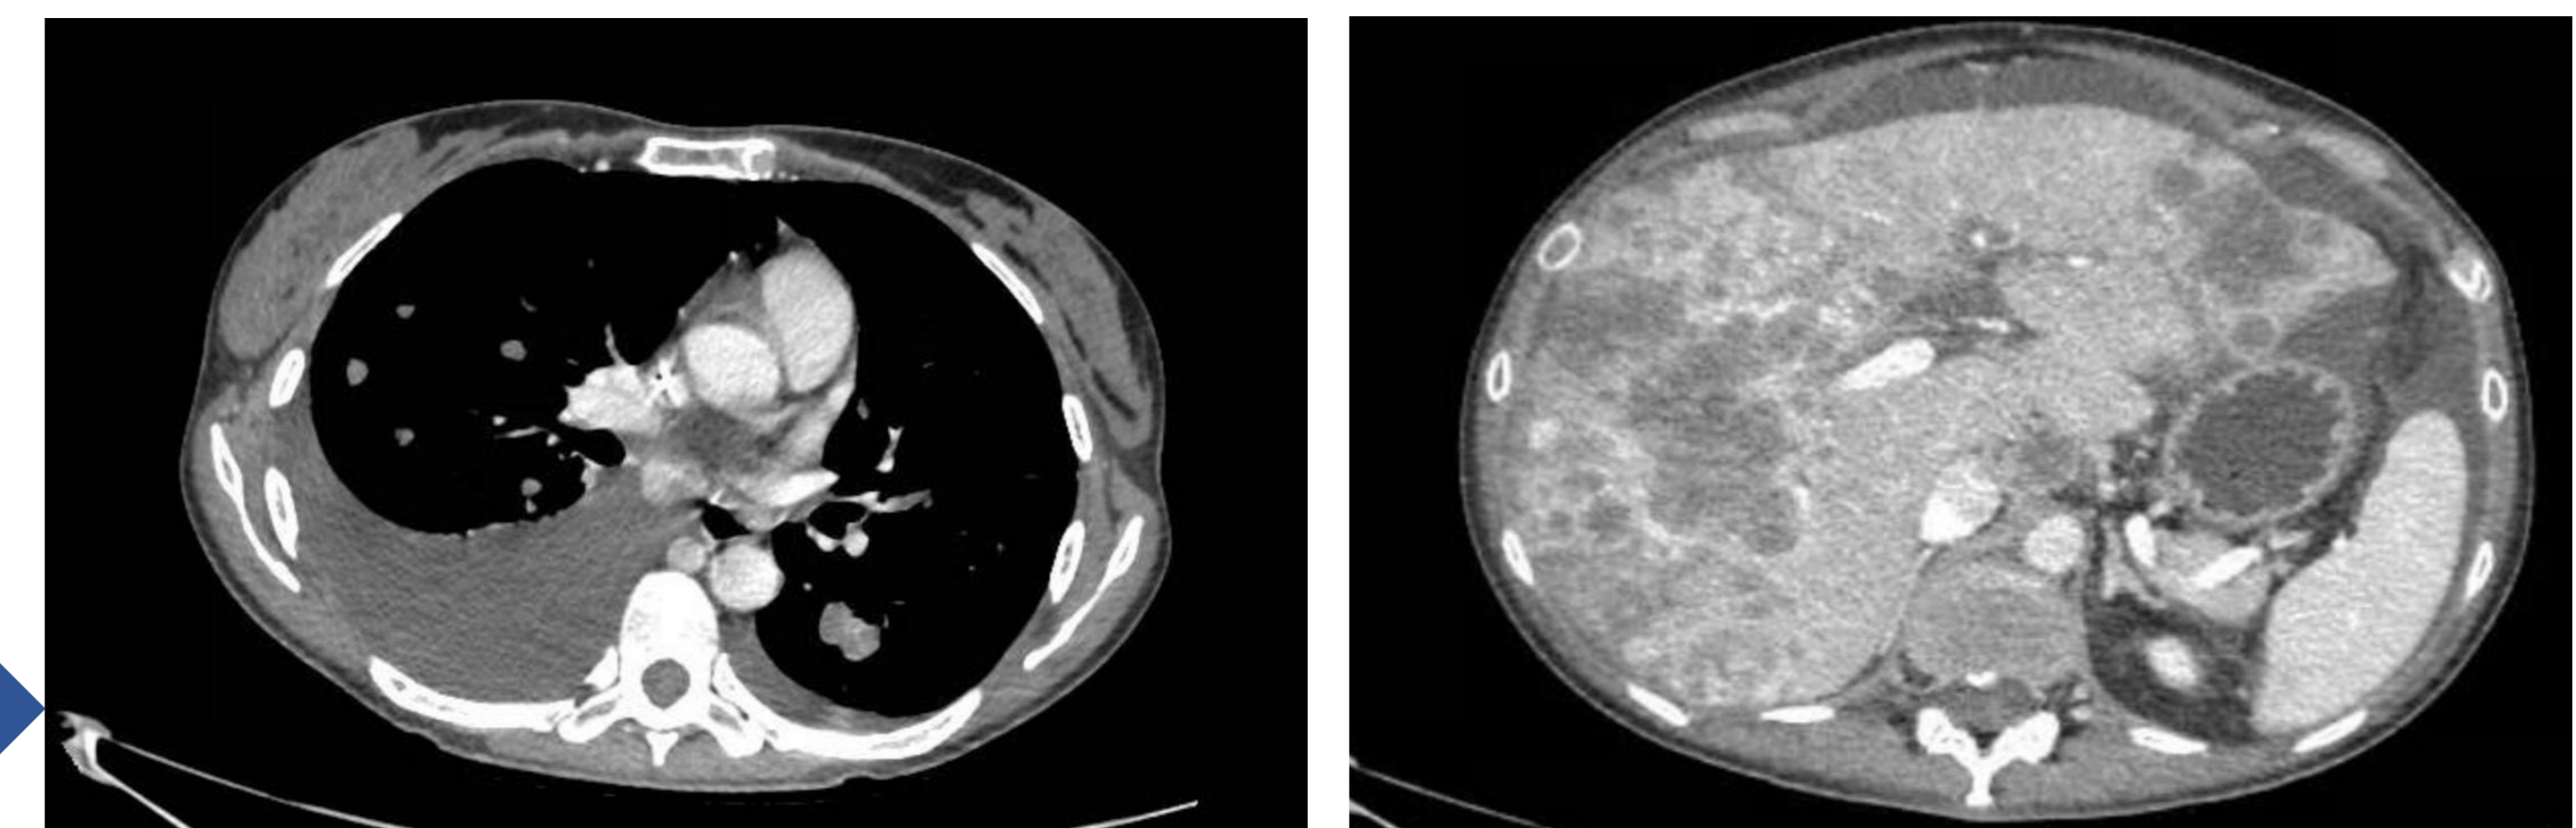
Evaluation CT scan after the first cycle of nivolumab, ipilimumab and trametinib showing pleural, pulmonary, hepatic and ascitic hyperprogressive disease. Although the definition is controversial, the majority of authors coincide that a hyperprogression implies RECIST progression in less than 2 months from the initiation of therapy, a $\geq 50\%$ increase in tumor burden and a ≥ 2 -fold increase in tumor growth rate or kinetics.(7). The present case fulfilled all of these criteria.
